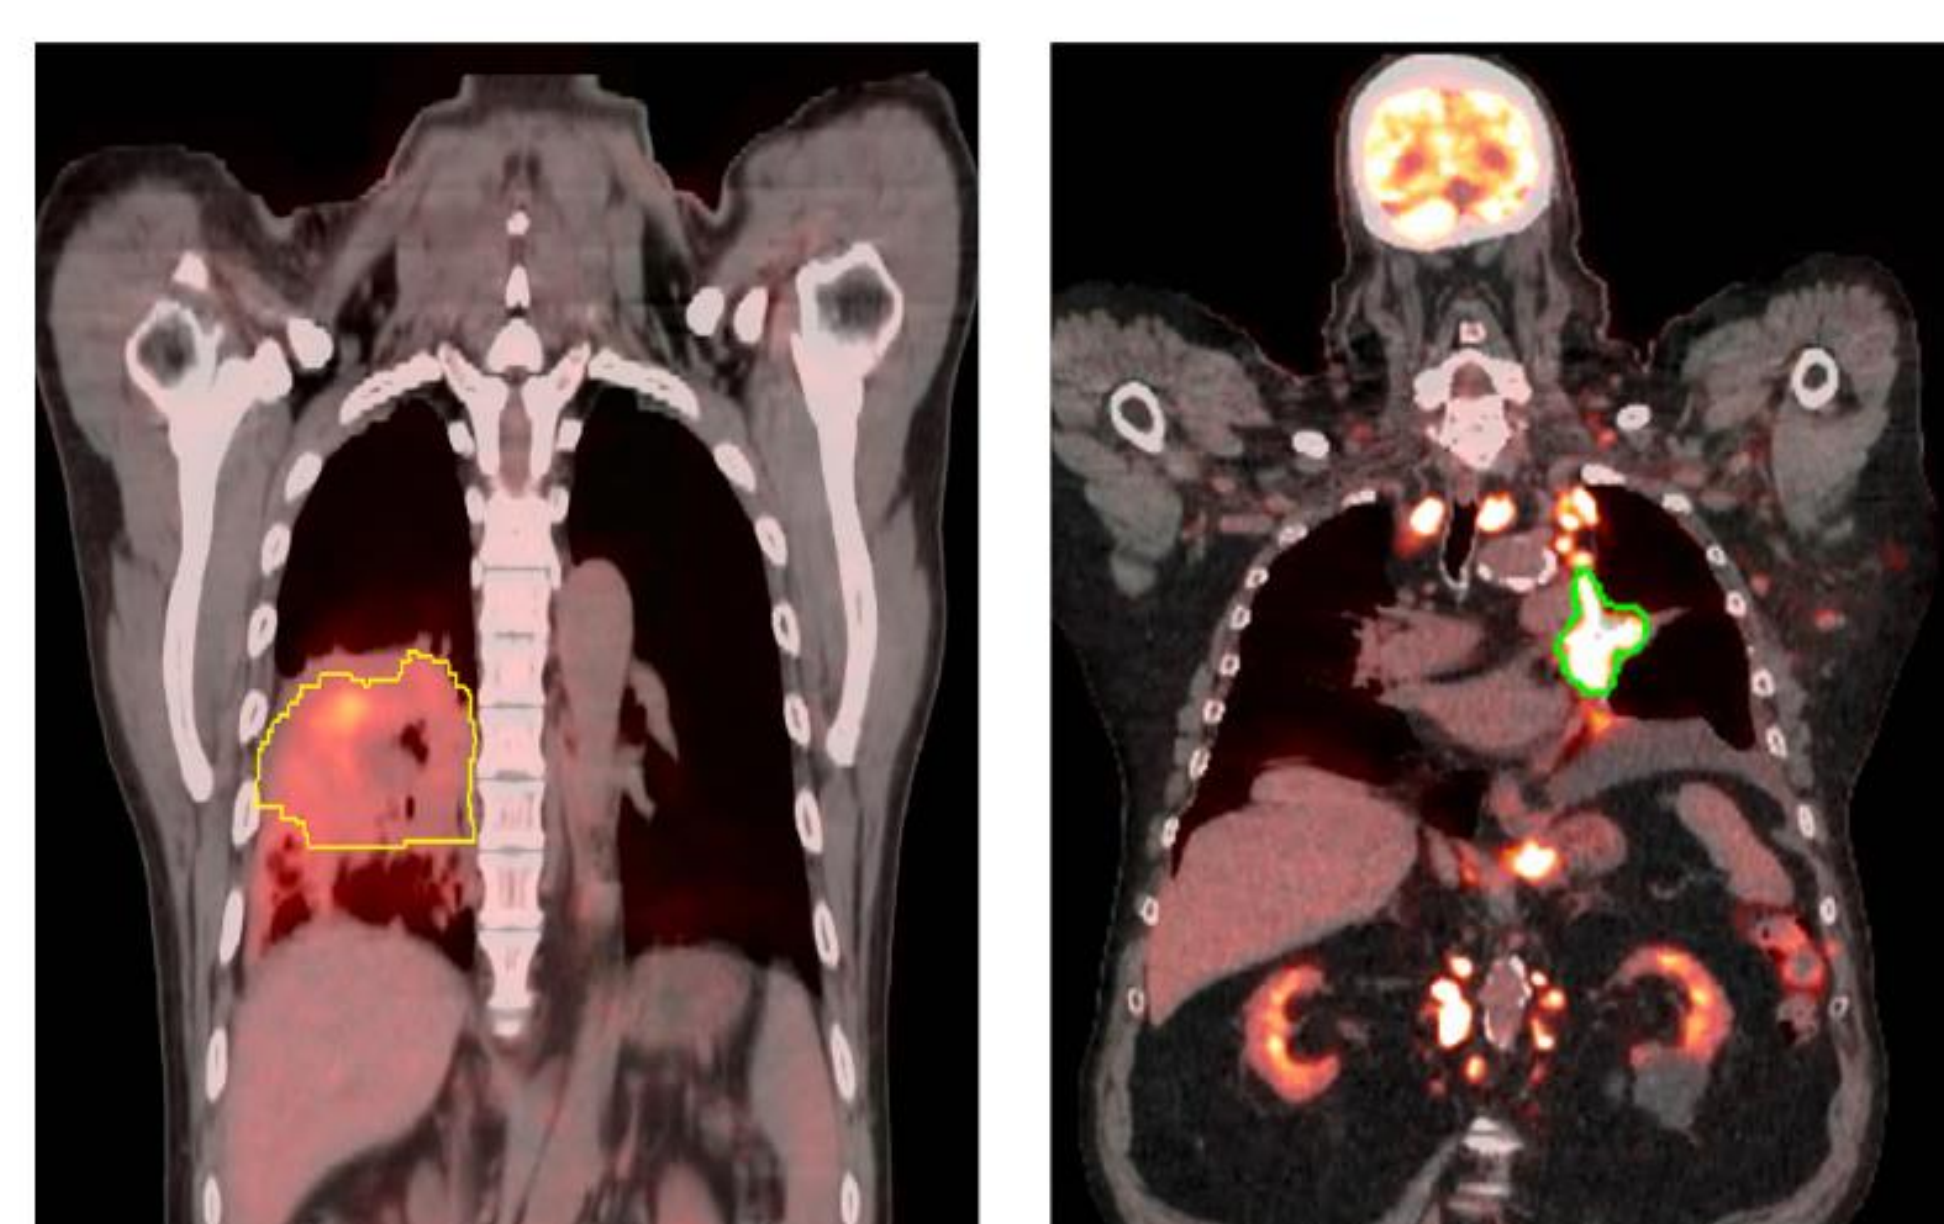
FDG-PET/CT of locally-advanced (left) vs. metastatic (right) NSCLC; analyses restricted to the primary lung tumor
